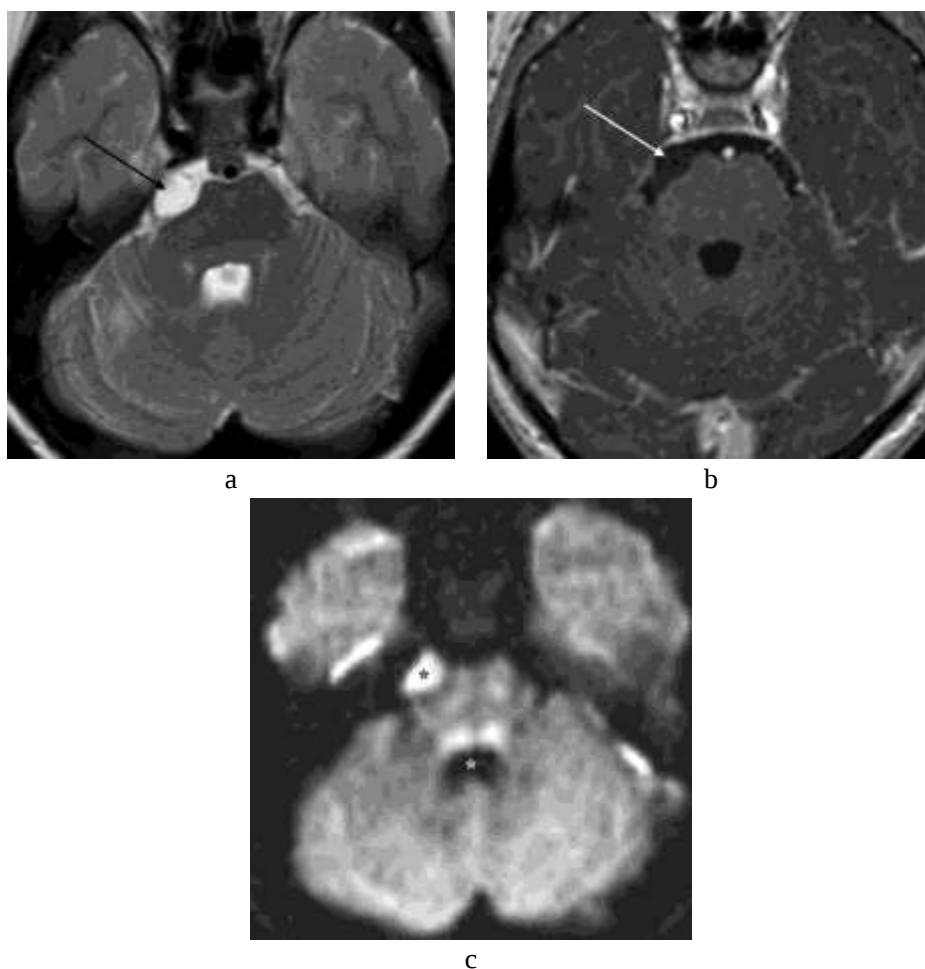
Epidermoid cyst; axial T2-weighted (a), contrast-enhanced T1-weighted (b) and echo planar DWI (c) sequences at the level of the CPA / pontine cistern. A small lesion with CSF like signal on T2 and T1+Gd in the right CPA / pontine cistern is shown (arrows). DWI highlights the finding which show a typical bright signal (black asterisk) if compared to CSF (white asterisk within the IV ventricle).
